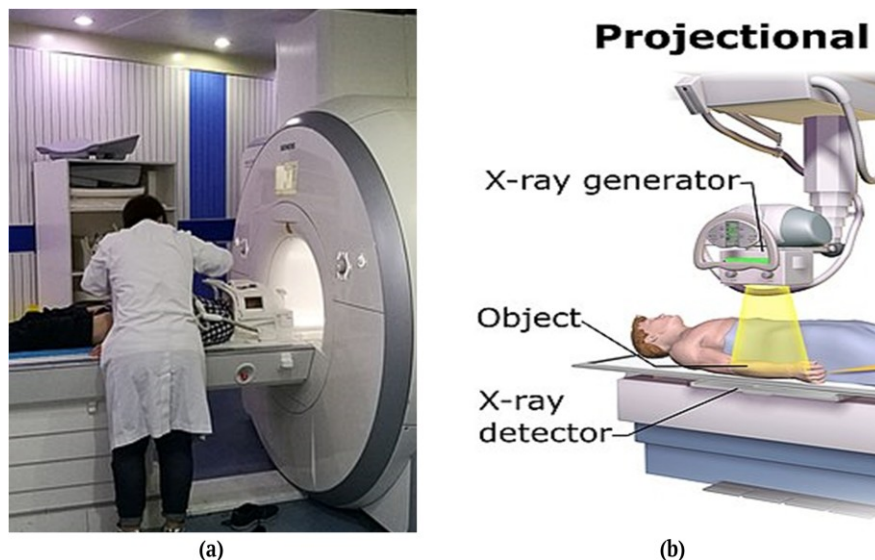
Medical imaging technologies in the diagnosis of brain tumors. (a) MRI scanner and (b) X-Ray scanner.
